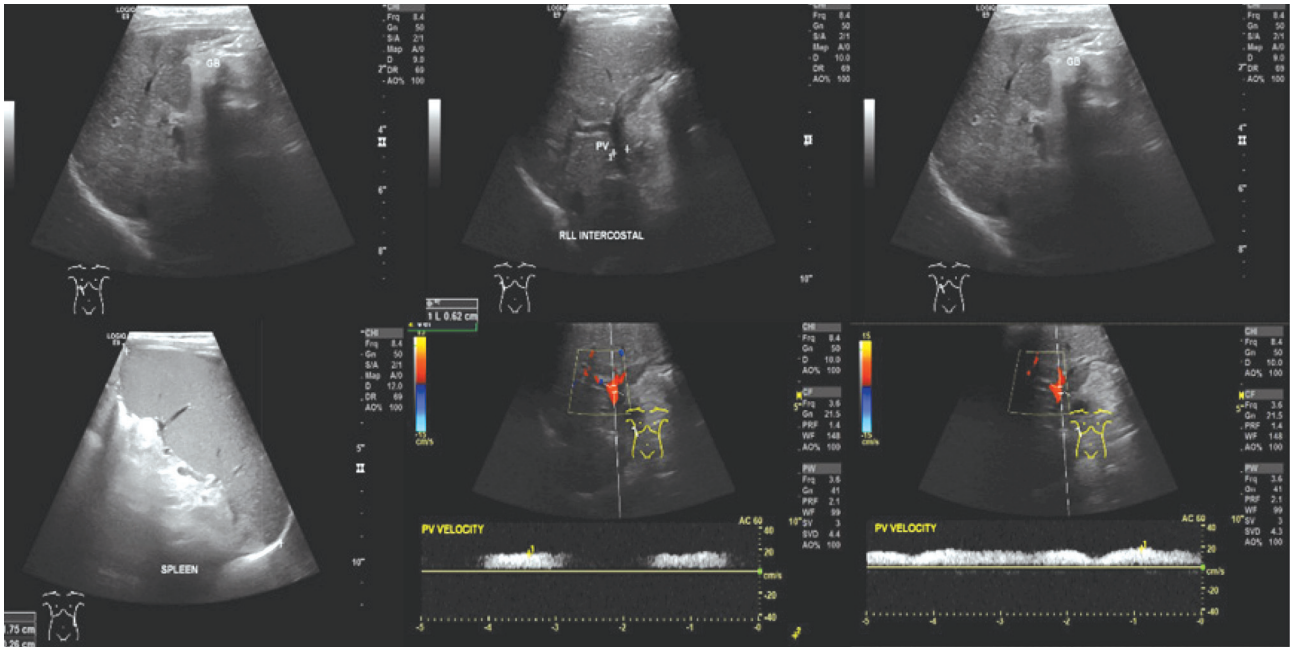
Abdominal ultrasound showed cirrhotic hepatitis with portal hypertension.
